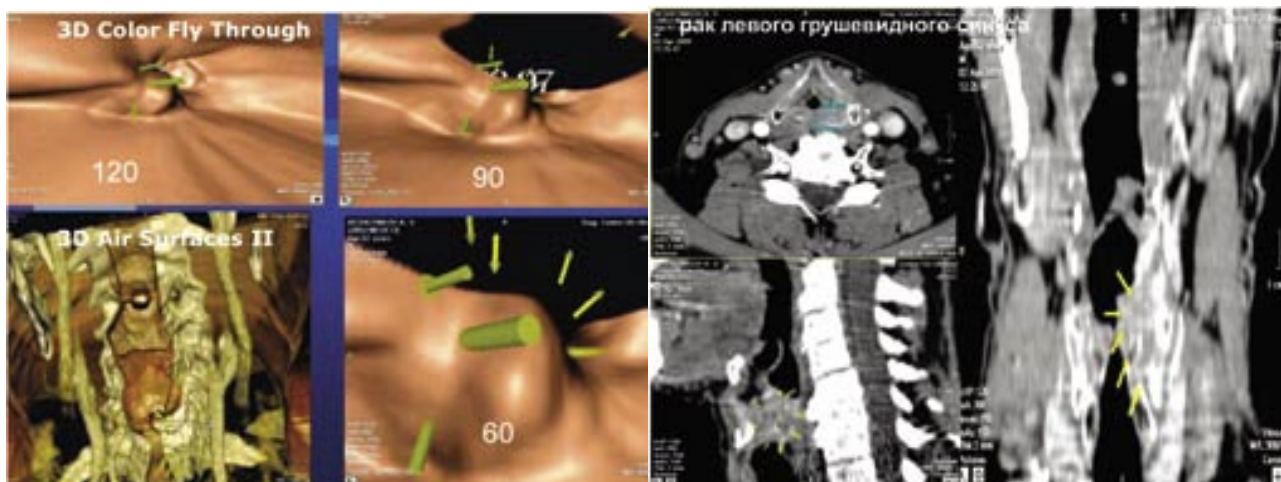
Multispiral CT: laryngopharyngeal cancer. Three—dimensional colour fly—through visualization.
